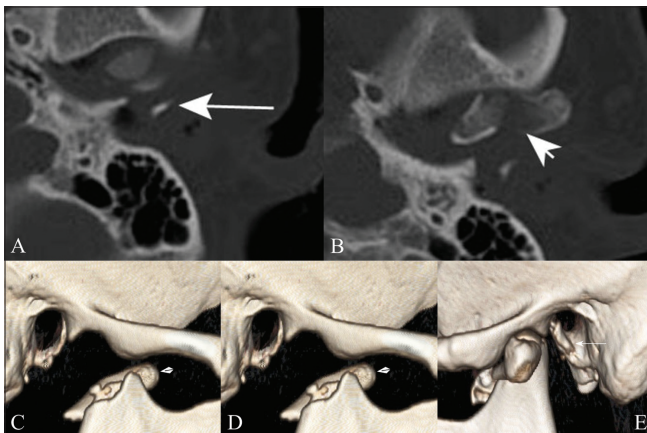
(A-E): EAC injury: Axial HRCT image (A) shows fracture of the anterior wall of left EAC (arrow). Axial HRCT image (B) shows fracture and subluxation of the left TM joint (arrowhead). Volume rendered images (C-E) show a dislocated right TM joint (arrow in C and arrowhead in D) and subluxed left TM joint with a fracture fragment (arrow in E)
